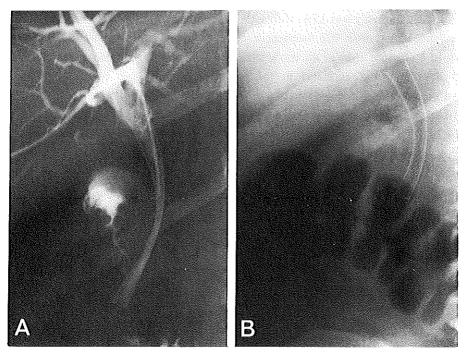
(a) Cholangiogram after insertion of a Wallstent endoprosthesis in a patient with pancreatic carcinoma. (b) Plain abdominal radiograph four days after insertion demonstrates further expansion of the stent.
